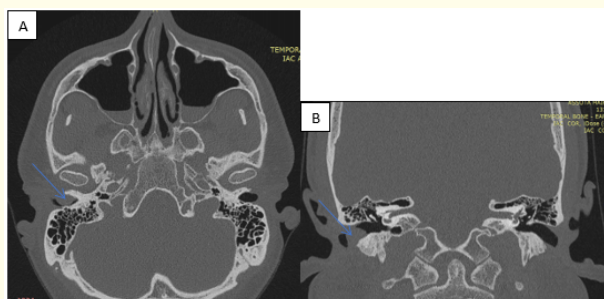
HRCT scans of the ears demonstrating the RT soft tissue fullness (arrow), A-axial, B-coronal view.
